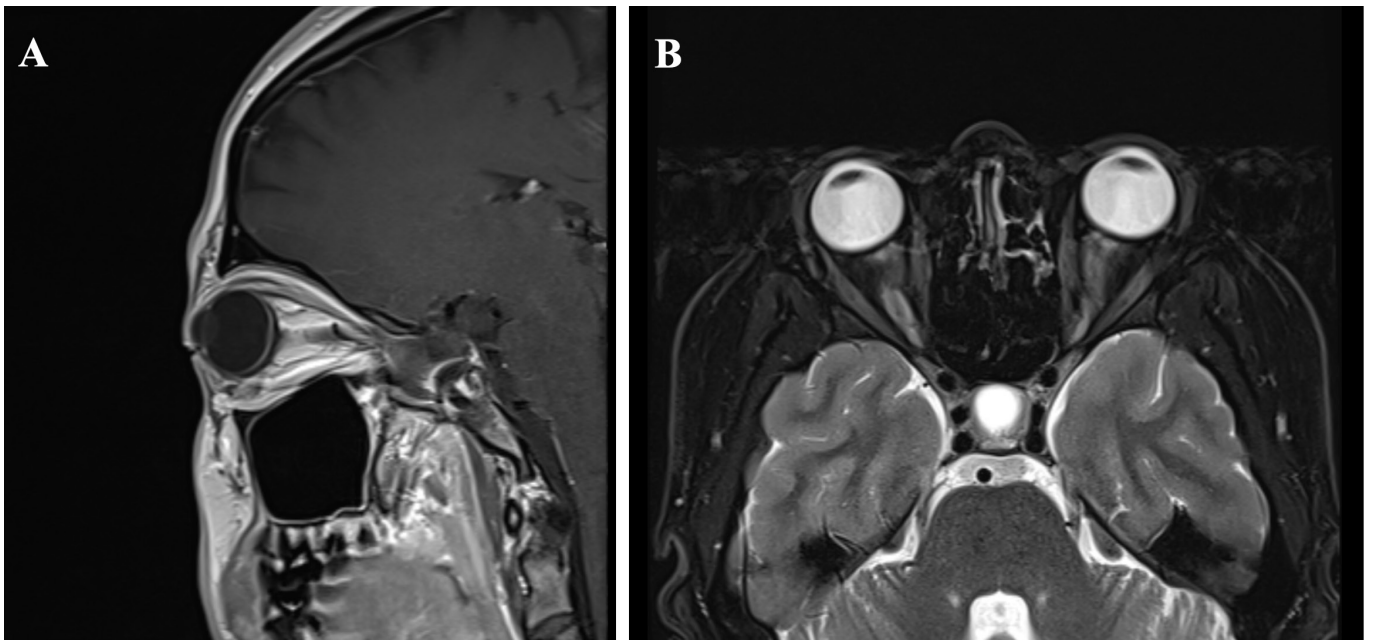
Sagittal T1 (A) and axial T2-weighted (B) orbital magnetic resonance imaging
